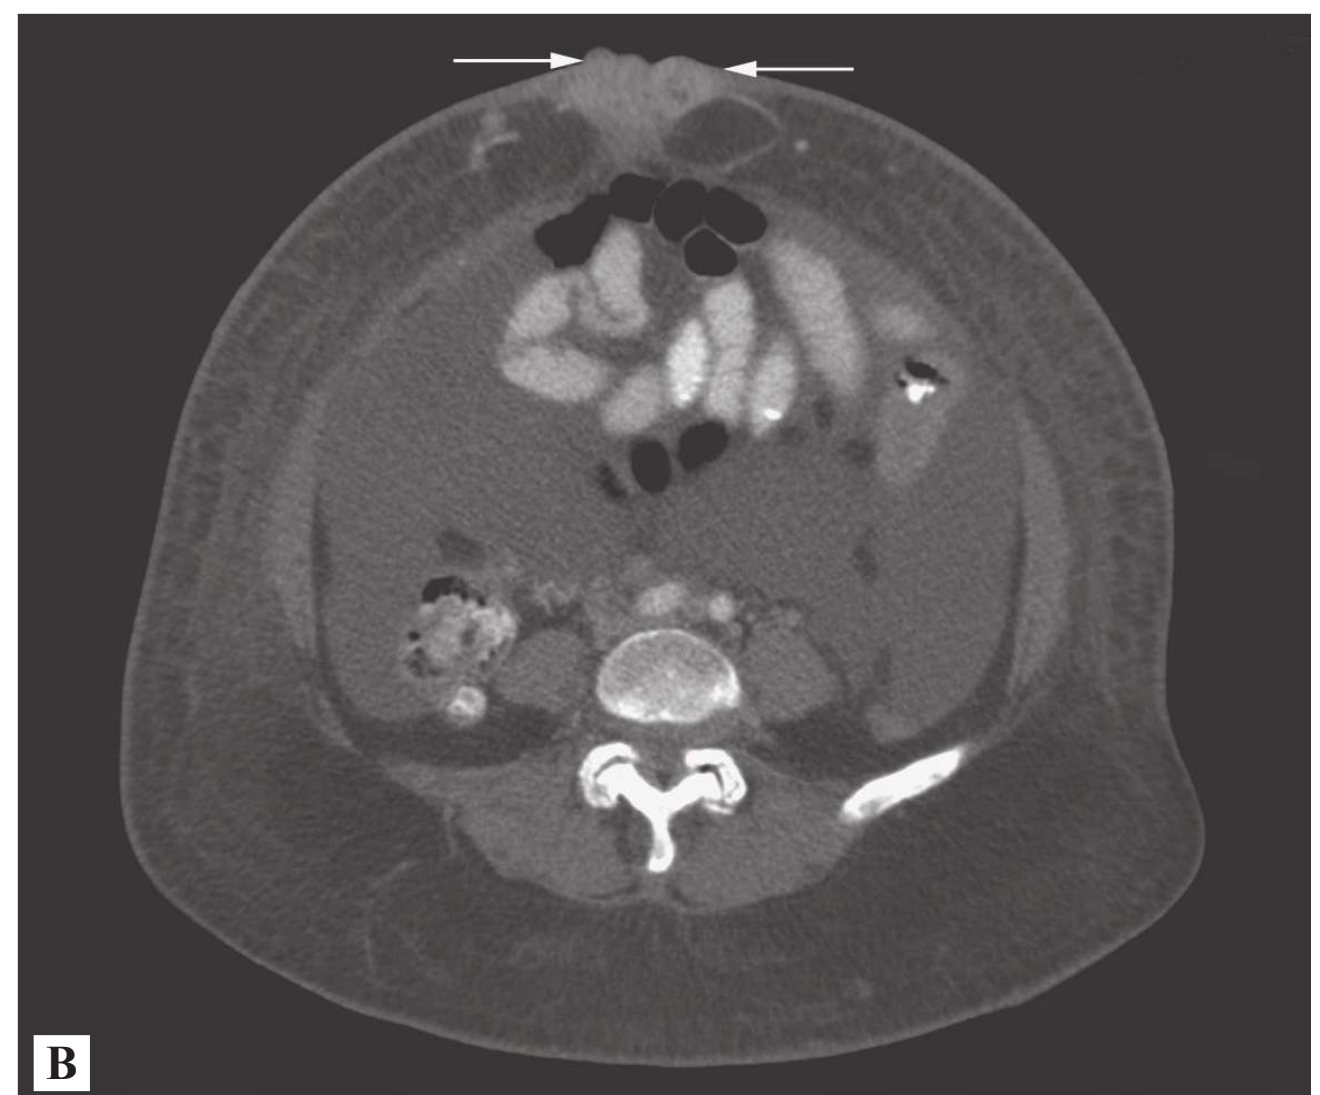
■ Sister Mary Joseph Node. This 63-year-old woman presents with abdominal swelling and ascites. She was diagnosed with ovarian cancer. Axial CT scan of the abdomen at the level of the umbilicus demonstrates ascitic fluid and the umbilical nodularity (arrows). (Photo contributor: R. Jason Thurman, MD.)
